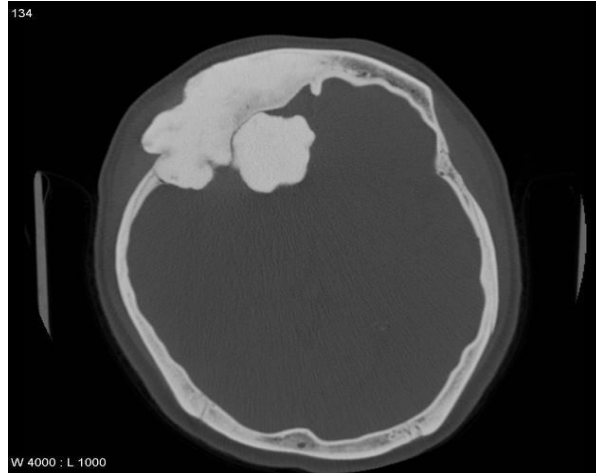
shows axial CT image bony window with osteoma in frontal bone(<https://radiopaedia.org>)
